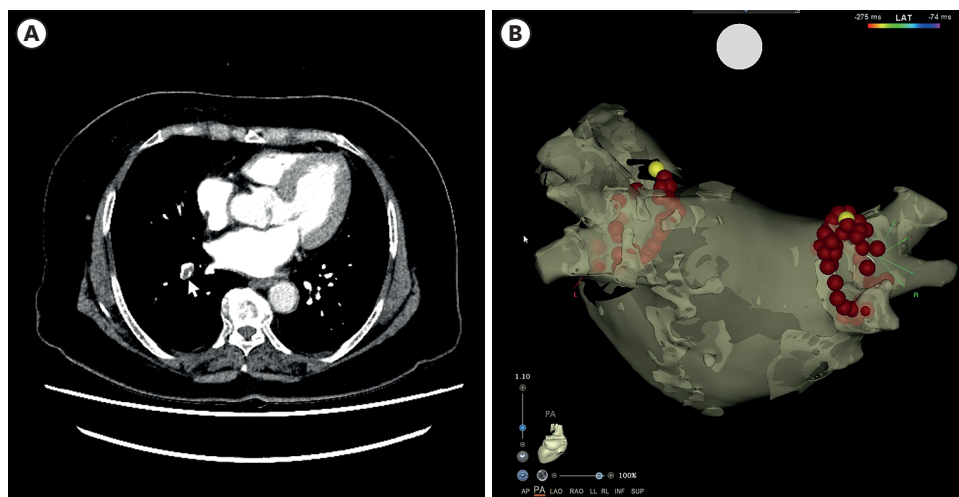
Pulmonary thromboembolism and Pulmonary vein isolation of 3D electroanatomic mapping. (A) Cardiac computed tomography showed a thrombus (white arrow) in the right pulmonary artery. (B) Four PVs isolation for treating paroxysmal AF.
